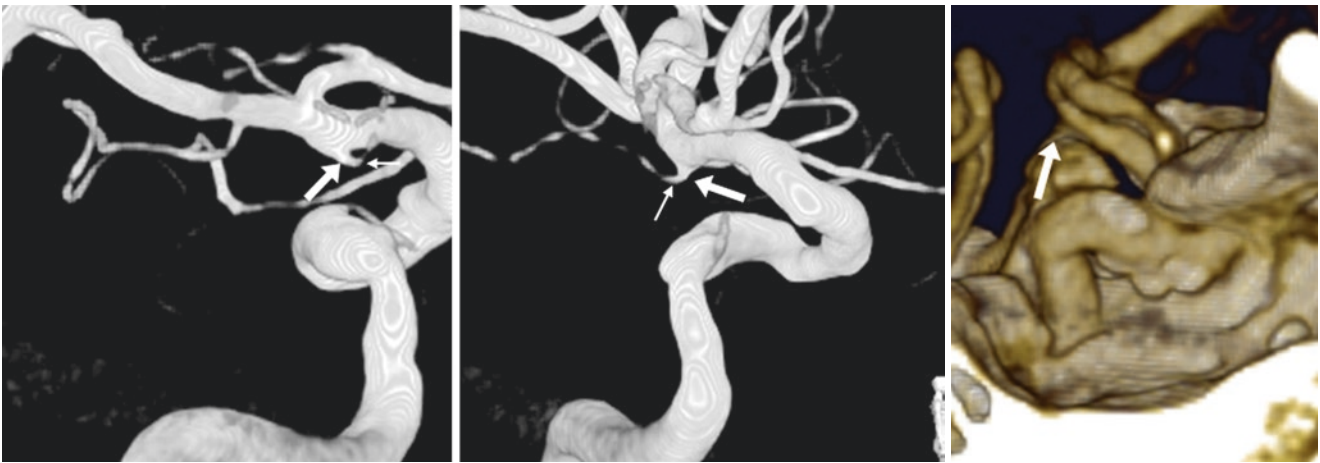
70-year-old with a tiny (<2 mm) PcoA segment infundibulum (*arrows*) seen on a catheter 3DDSA AP view (*left*) and right lateral view (*middle*), but not visualized on a 3D VR CTA right lateral view (*right*), most likely because of the multifocal atherosclerotic calcifications. Note the tiny PcoA arising from the apex of the outpouching (*thin arrows*)
